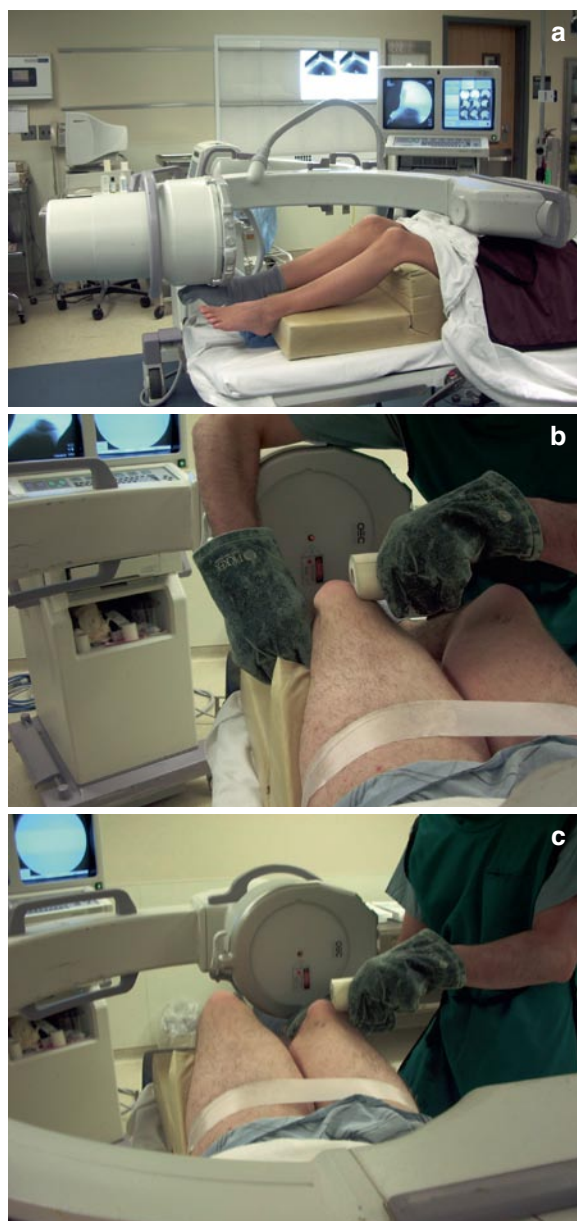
(a) The image intensifier is placed in the horizontal position and the knees are flexed about 30° – 40° for an intraoperative stress radiograph. (b) For a lateral stress radiograph, the knee is stabilized with one hand to prevent external limb rotation and a force is applied to the medial side of the patella, while the radiograph is taken. (c) For a medial stress radiograph, the knee is stabilized medially to prevent rotation while stress is applied to the lateral side of the patella
